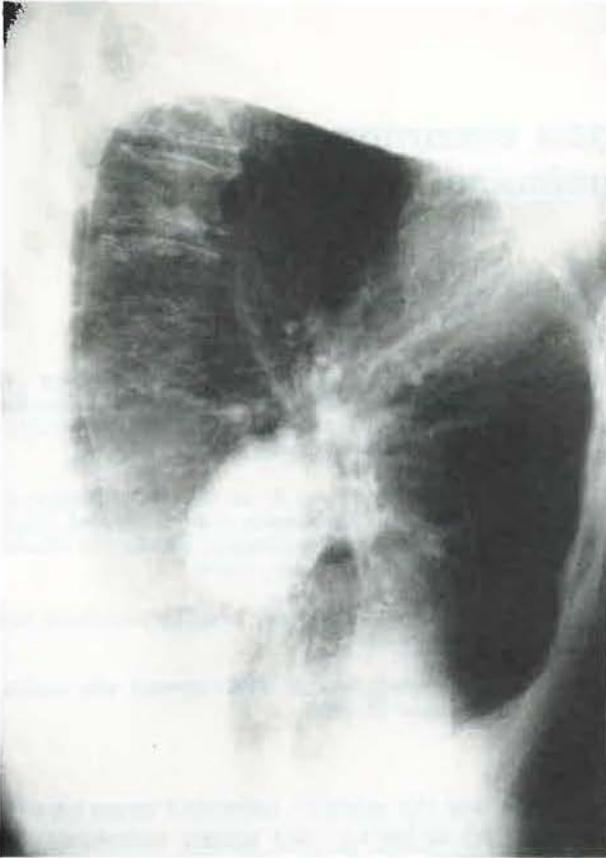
Lateral chest roentgenogram: the large mass is probably located in the major fissure posterior of the hilum. There is a small pneumothorax with a pleural effusion.
